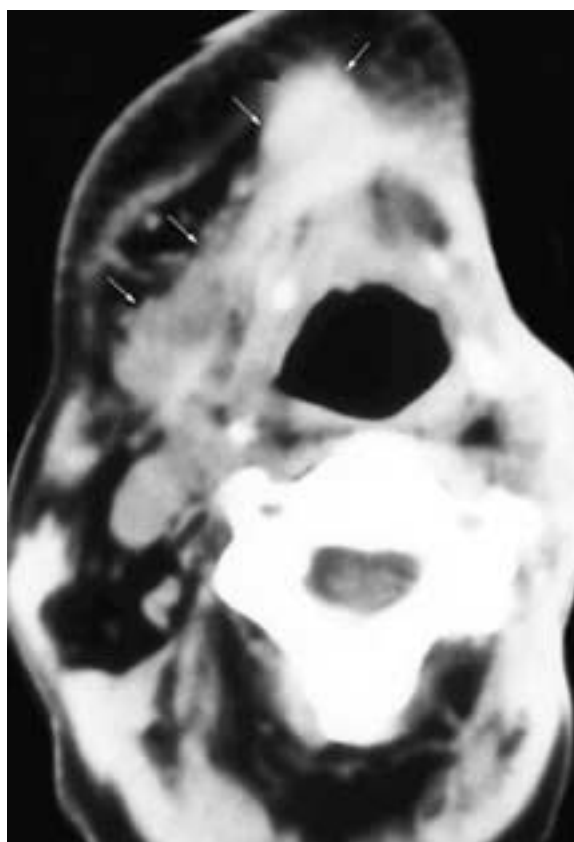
Axial contrast-enhanced CT scan on a patient who has had a left radical neck dissection. A soft-tissue fullness is present at the scar line (*arrow*). Although a recurrence was not clinically suspected, fine needle aspiration revealed a recurrence of squamous cell carcinoma.
